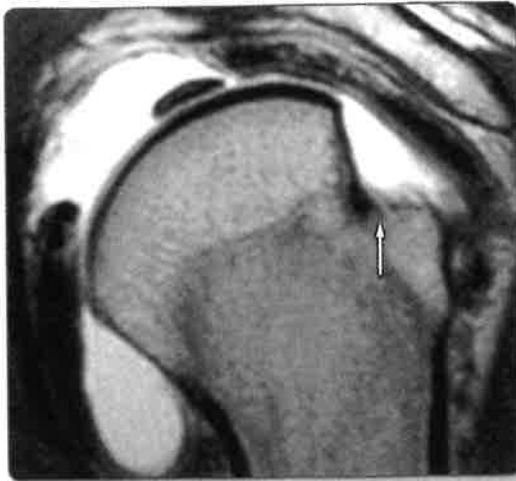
Magnetic resonance imaging (MRI) in shoulder instability.
